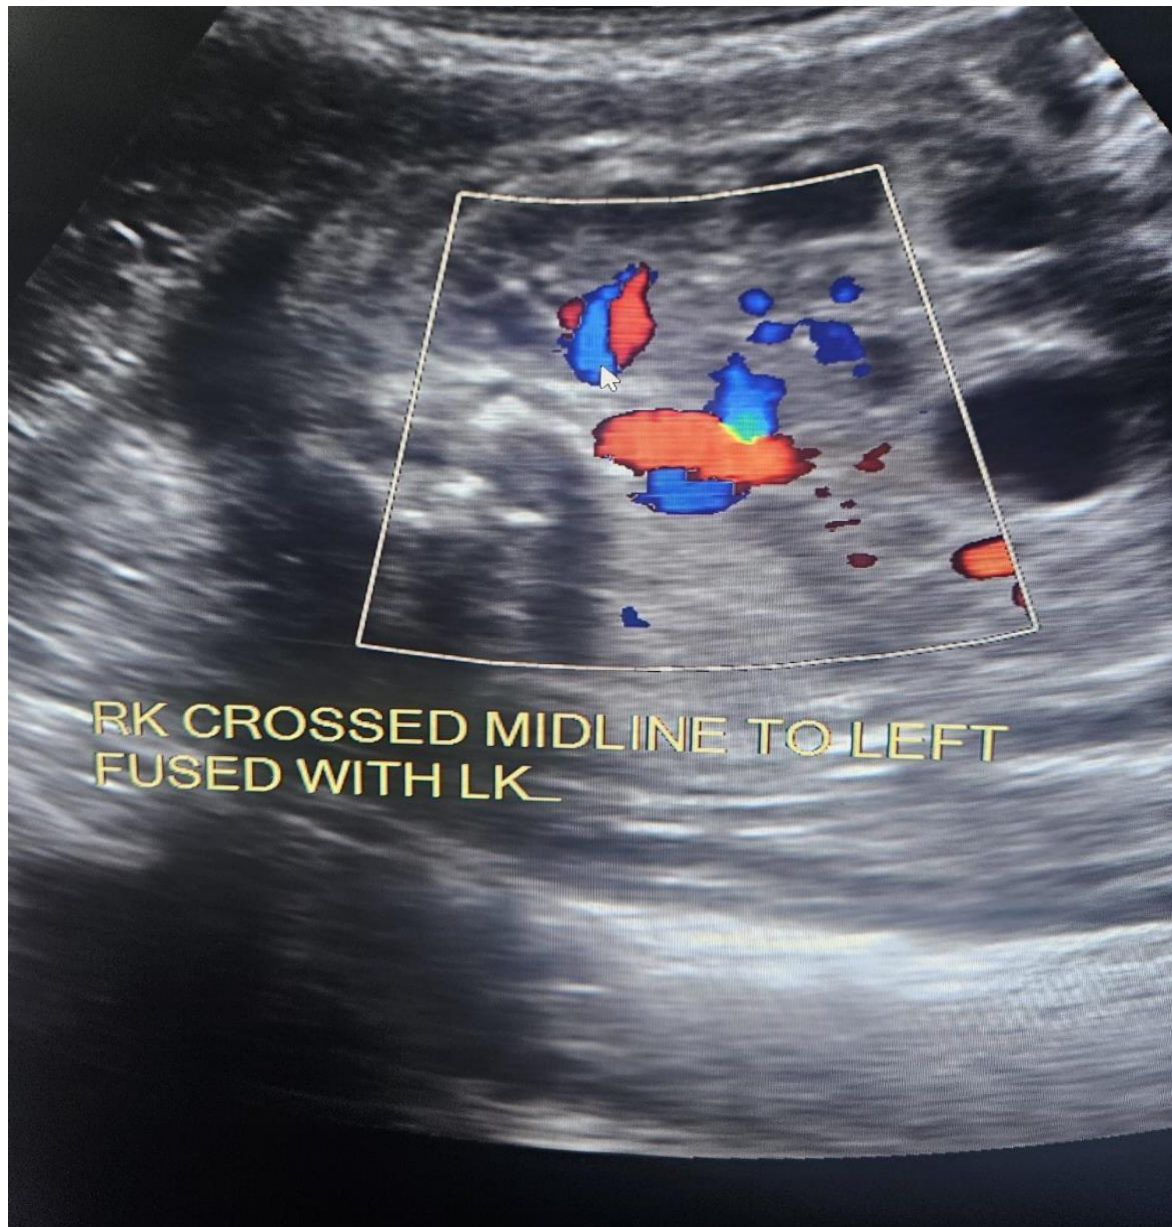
Case report, (Antenatal) Image Ultrasonography, Renal system.
